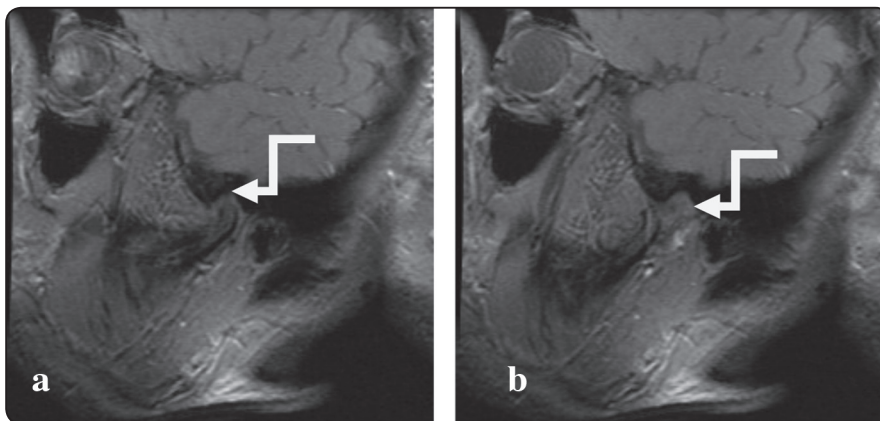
Postoperative Dynamic MRI views (12 months) showing recapture disc position over the condyle in a) closed mouth position b) opened mouth position (white arrows)
